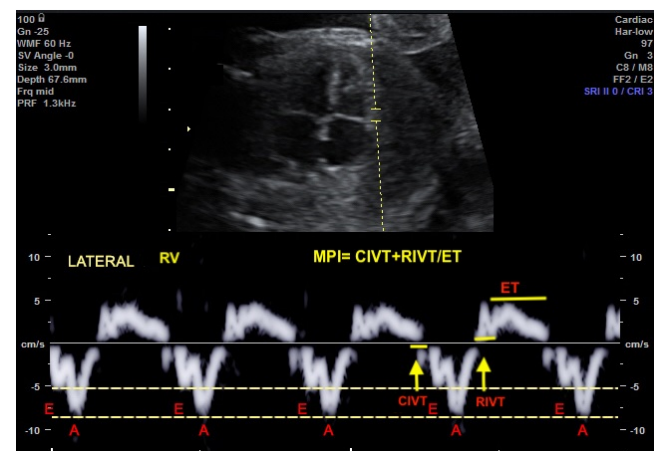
Myocardial tissue Doppler velocities and myocardial performance index obtained by spectral tissue Doppler (MPI') of the right ventricle. E' wave (early diastolic annular peak velocity), A' wave (late-diastolic annular peak velocity) and S' wave (systolic annular peak velocity).
